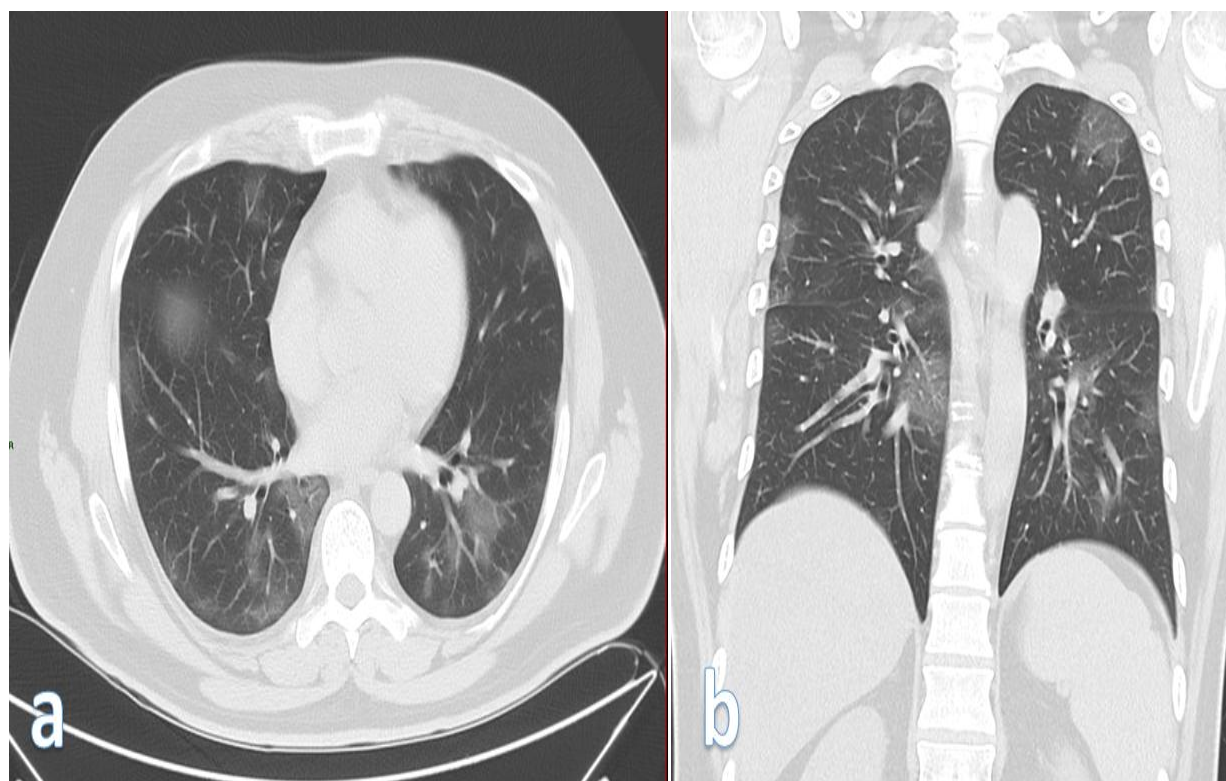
a, b. Axial and coronal Chest CT images of a 72year old male COVID-19 patient demonstrating ground-glass opacities.
